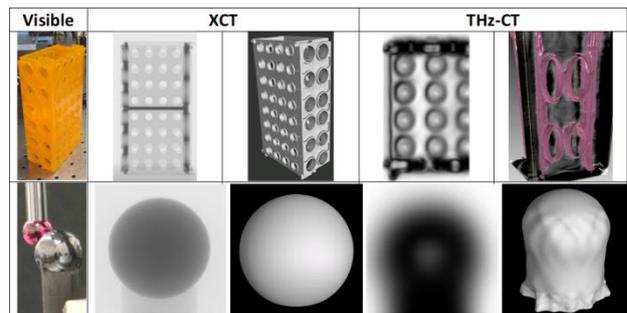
Comparison between optical, XCT and THz-CT images of the same objects
